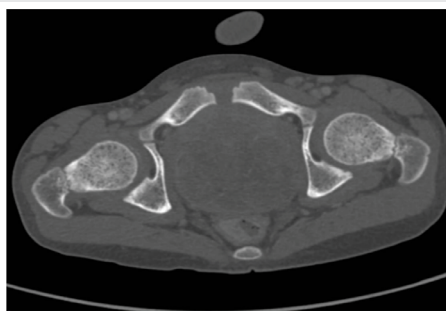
Computed tomography of prostate showed homogenous soft tissue mass measuring 4x5cm in size (arrow).
